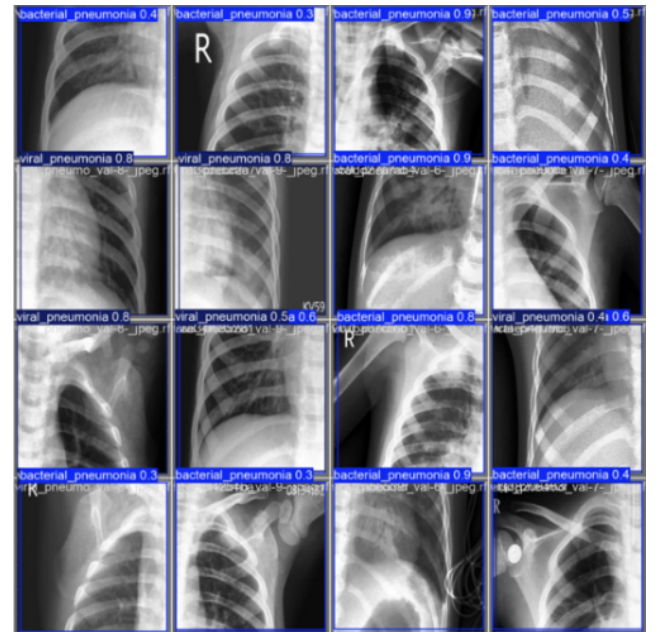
Visualization of ASPIRE-YOLOv12 detection results on X-ray test images
